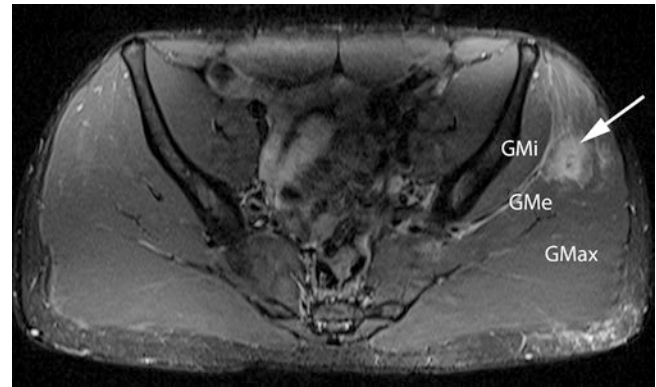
Myotendinous injury. A 23-year-old soccer player with acute buttock pain. Axial T2FS MR image shows left gluteus medius myotendinous tear (arrow). The distal tendon was normal and intact
